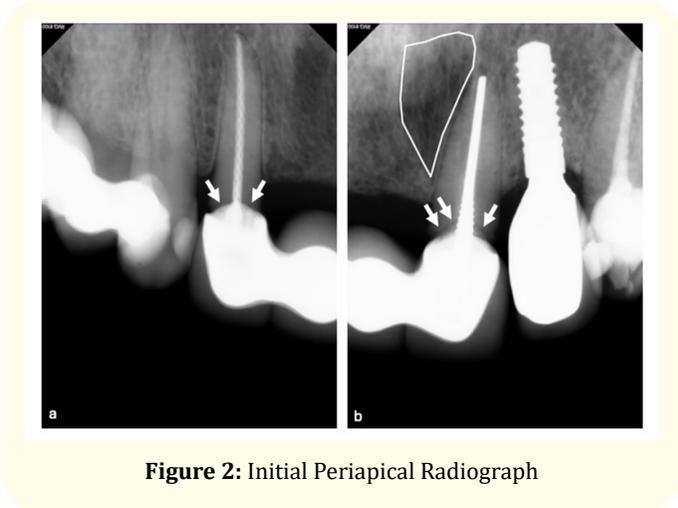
Initial Periapical Radiograph
